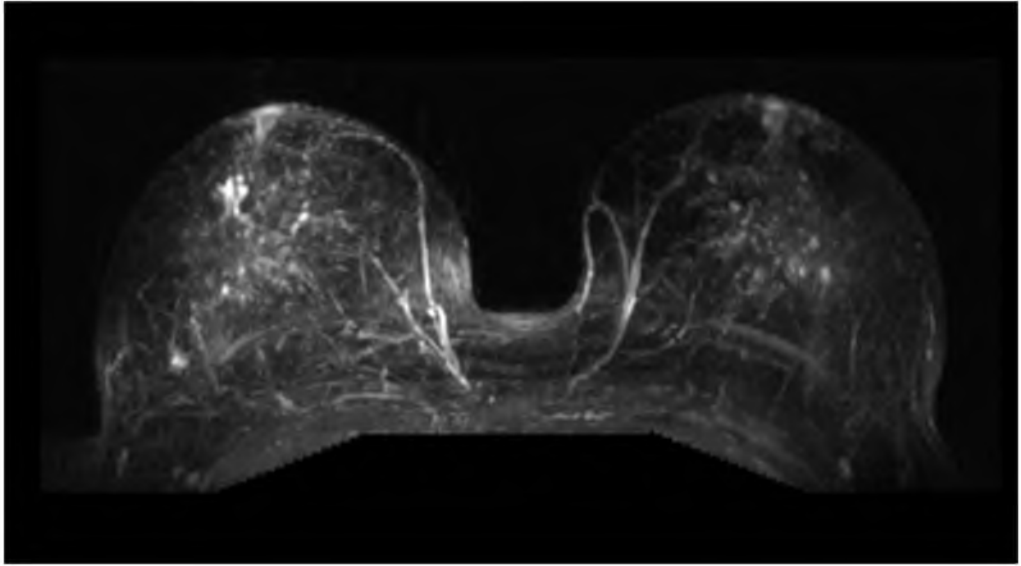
Maximum intensity projection of subtracted contrast-enhanced breast MRI
